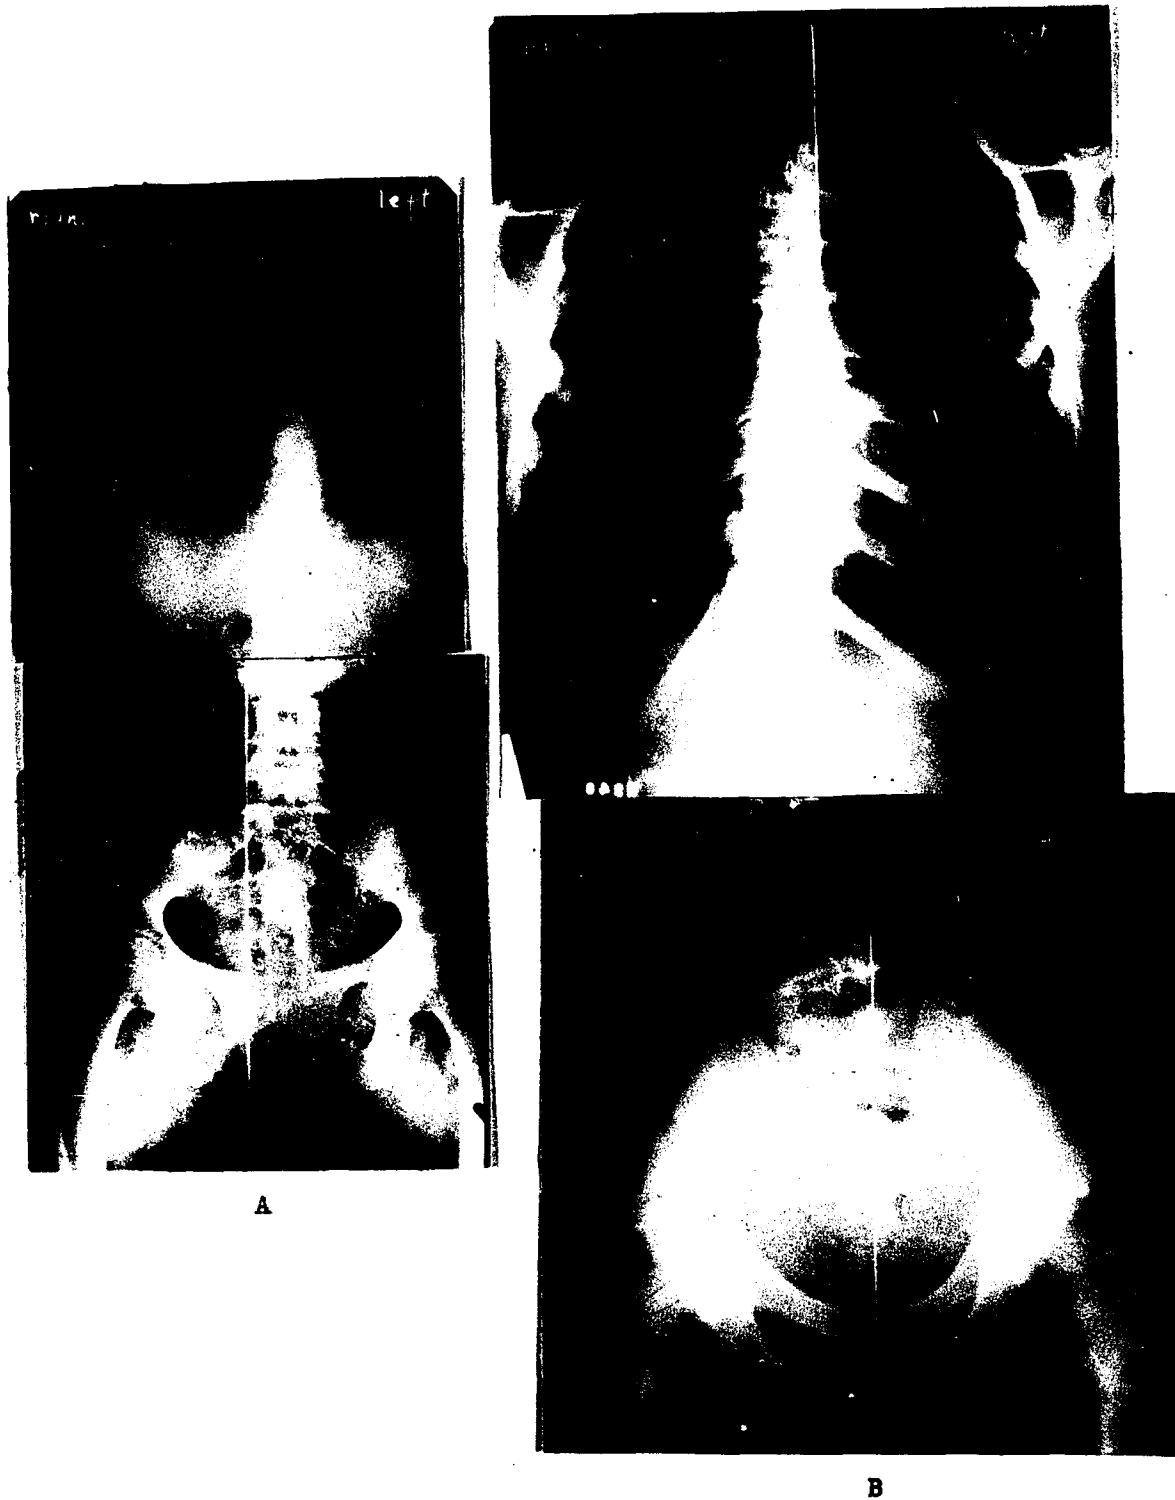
Bilateral skeletal alignment. A is a radiograph of a skeletal structure which approximates bilateral symmetry; B is a radiograph which shows the general pattern of bilateral skeletal asymmetry. The subject of this radiograph swayed to the left in the interim between the exposure of the pelvic and thoracic x-ray films.
